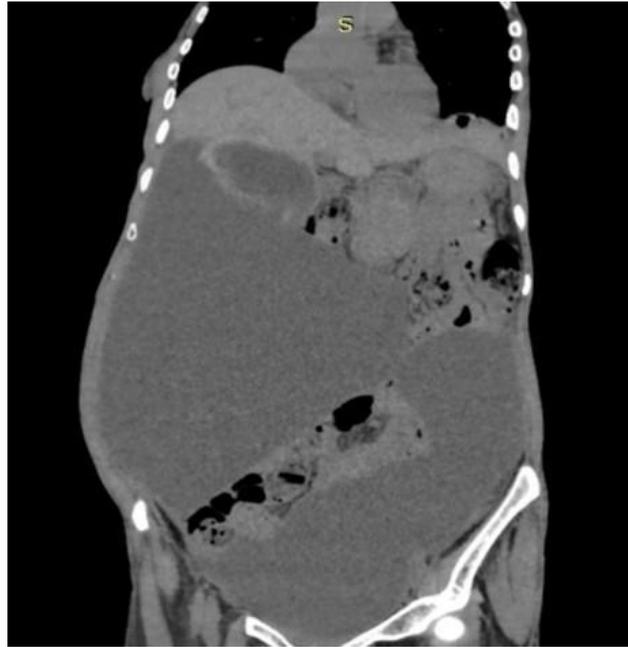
Non contrast CT , Sagittal section : showing a well defined cystic lesion with thin walls and internal laminated septations. There is a small defect in its wall communicating with massive peritoneal ascites s/o rupture into peritoneal cavity associated with peritoneal/omental thickening & smudging denoting peritonitis.
